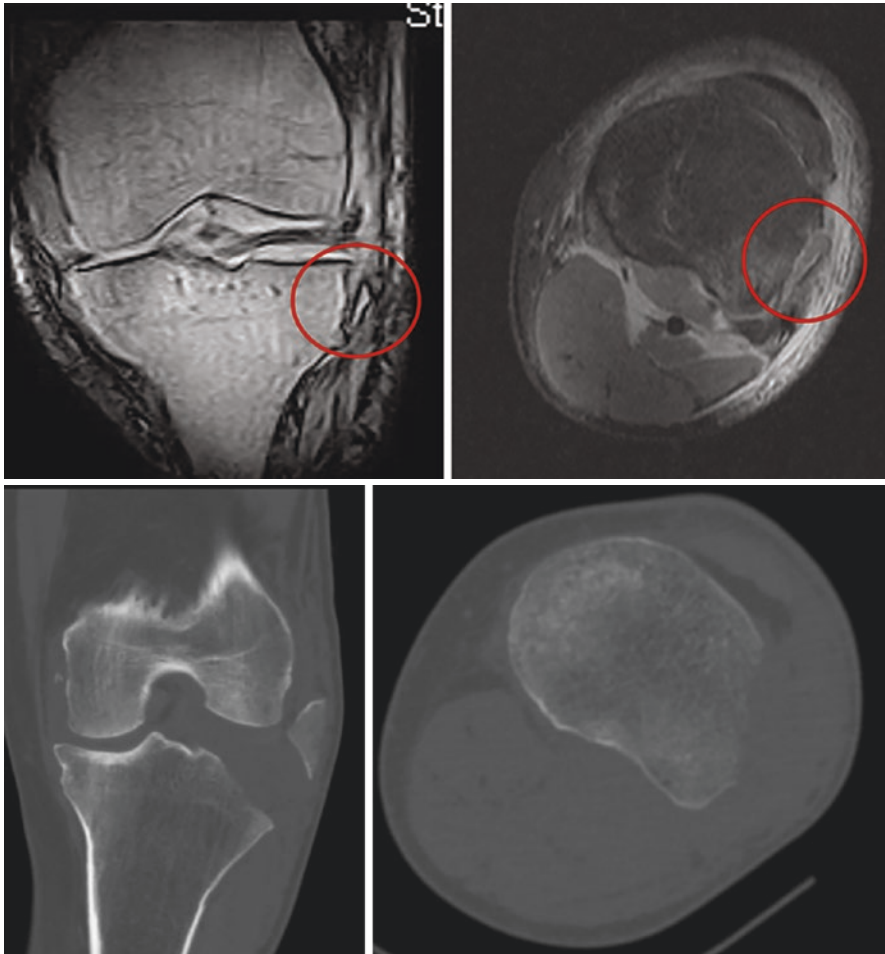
Segond's fracture on MRI and CT in axial and coronal view
